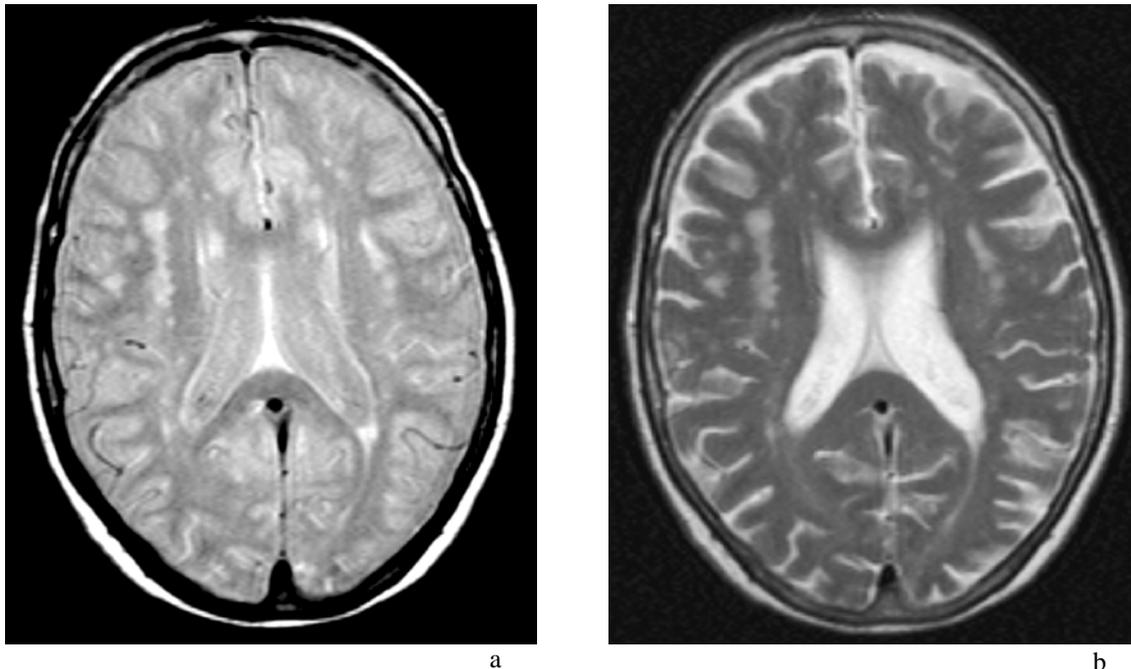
Proton-density (a) and T2-weighted image (b) of a healthy subject with subcortical white matter hyperintensities.
